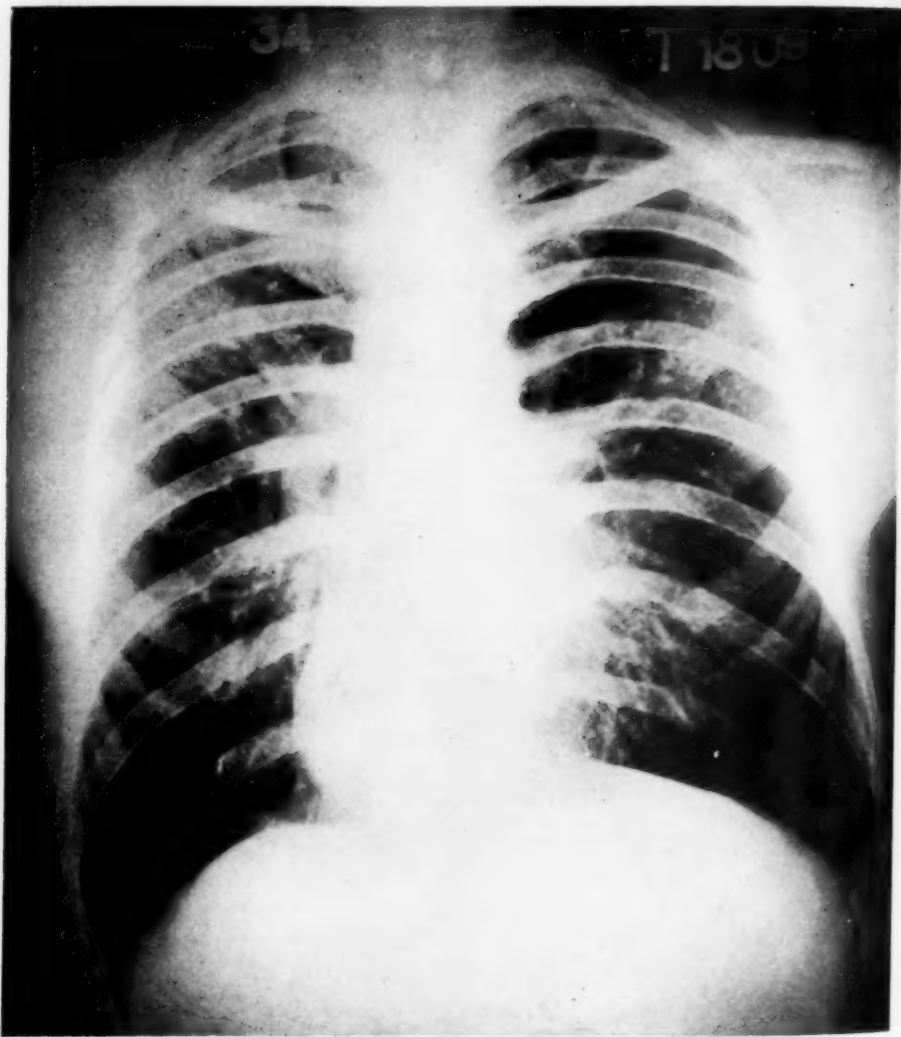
Roentgenogram of chest, February 12, 1934.
